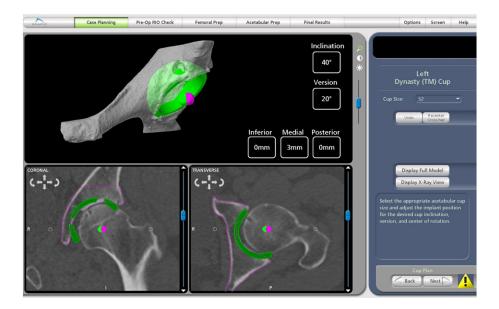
Preoperative plan on CT scan. The inclination and anteversion, size and center of rotation (COR) of the planned acetabular cup are determined with the relationship of the cup COR (green) to the arthritic hip COR (magenta) displayed. The horizontal numbers show the planned COR in all planes with the horizontal COR 3 mm medial to the hip COR.
